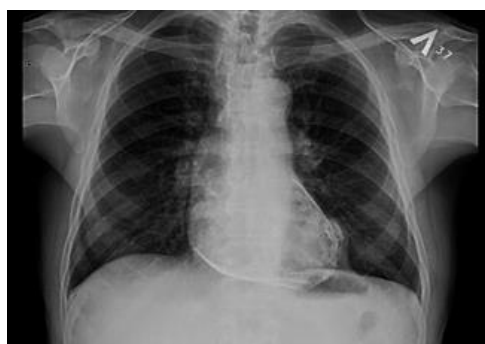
Radiograph of the chest.
